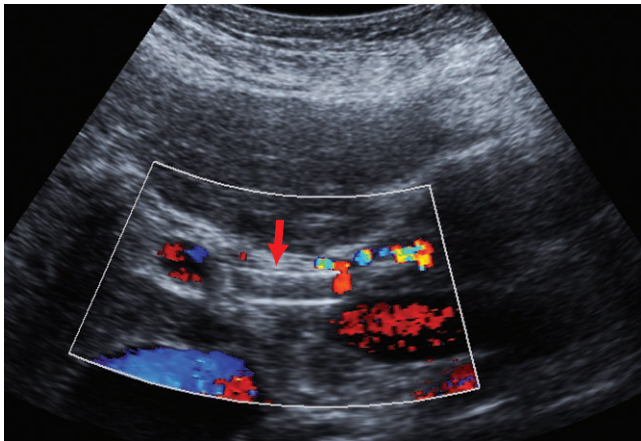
The color Doppler image of the porta shows lack of blood flow in the hepatic arterial stent (arrow) indicating stent thrombosis.
